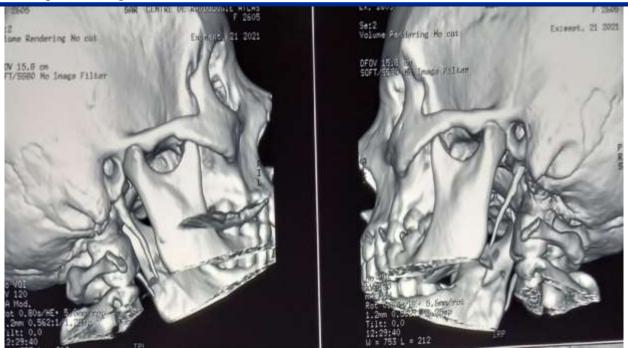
cervico-facial CT scan - 3D reconstruction - showing a styloid process bilaterally
